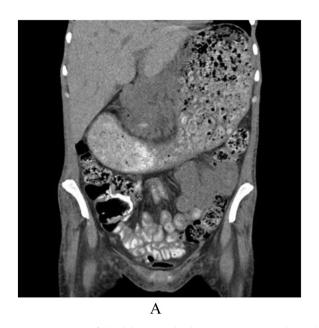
A). CT scan of the abdomen and pelvis on postoperative day 5 showing marked gastric dilation and gastric bezoar with increased stool burden in the colon (coronal view). B). CT scan of the abdomen and pelvis on postoperative day 10 showing resolution of the gastric distension (coronal view).
